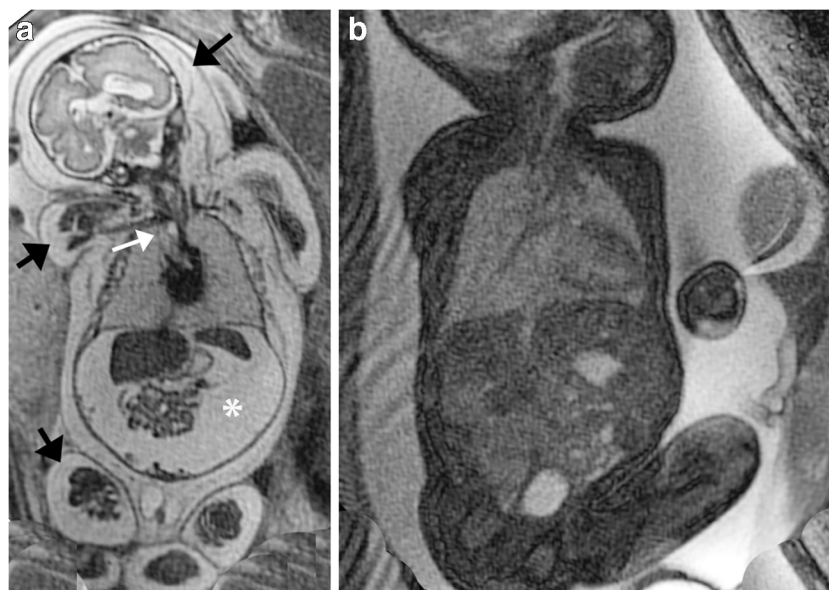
Evaluation of global mass effect exerted by the lesion onto the fetus. a Coronal single-shot turbo spin-echo (SSTSE) MR image in a 32-week fetus shows findings of congenital high-airway obstruction syndrome (CHAOS) secondary to a small bronchogenic cyst (*white arrow*) arising from the trachea and restricting the egress of fluid. Note that the heart is midline but compressed, and the lungs are hyperintense and enlarged, with flattening of the diaphragms, secondary to the retained fluid. Ascites (*asterisk*) and diffuse skin thickening (*black arrows*) are seen, consistent with hydrops. Oligohydramnios was also noted. b
